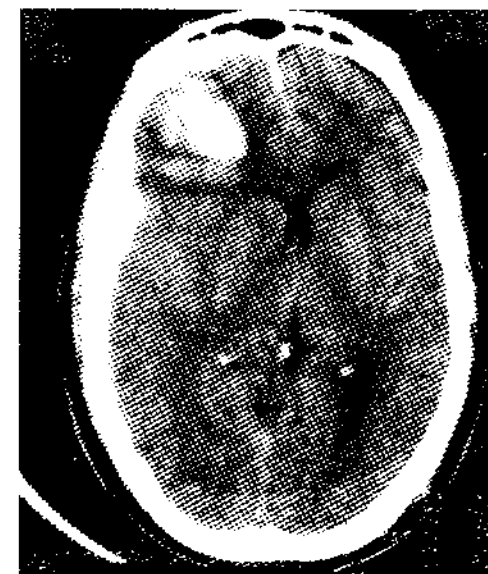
CT scan showing right frontal intracerebral haematoma
